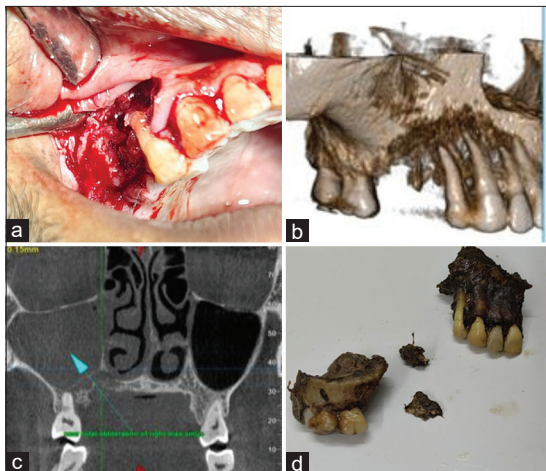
(a) Clinical intra-operative image showing inflamed soft tissue with friable bone, mobile teeth and missing 15. (b) CBCT image shows the right maxillary quadrant with missing 15 and 16, with peri-apical and inter-radicular bone loss. Erosion was noted along the buccal plate. (c) Radiographic image shows a hazy right maxillary sinus with communication from the palatal bone and peri-apical region of the molar tooth. (d) Surgical grossing of one of the cases showing fragmented necrotic maxillary bone with teeth attached
